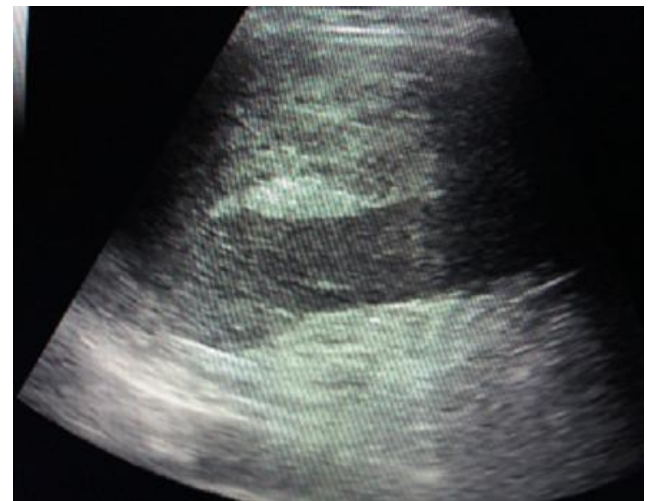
Ultrasound showing an echoic range of the splenic lodge
